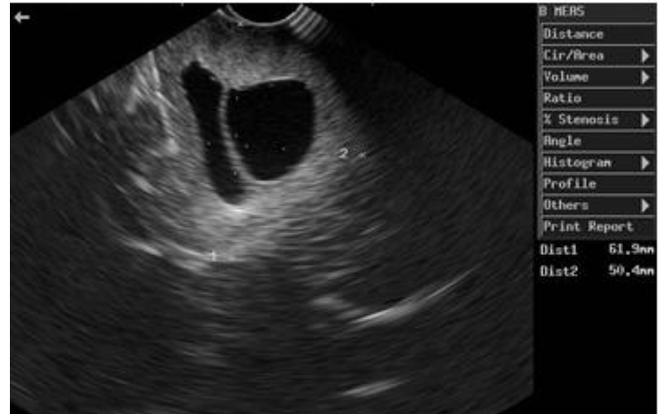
Intraoperative ultrasonography (tumor delineation)
